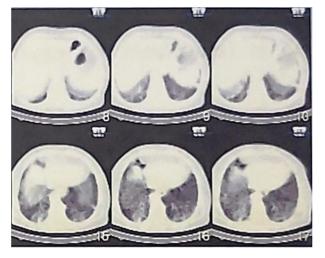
Chest-CT scan revealing air bronchogram associated with ranges of diffuse ground glass opacities.
